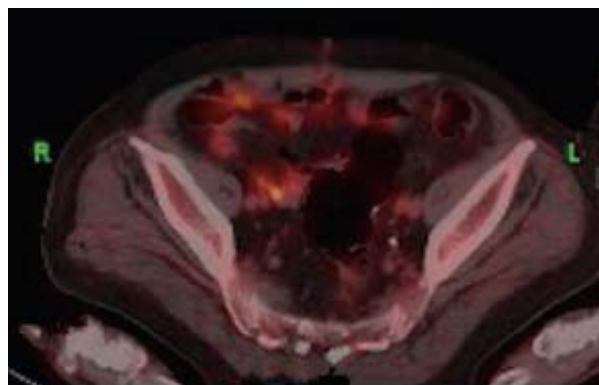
¹⁸F-FDG-positron emission tomography/computed tomography findings after treatment. Follow-up ¹⁸F-FDG-positron emission tomography (PET)/computed tomography (CT) showed complete remission of the MALT lymphoma. The elevated lesion at the anastomosis disappeared. No abnormal FDG uptake was observed at the colorectal anastomosis as well as the paracolic lymph nodes.
